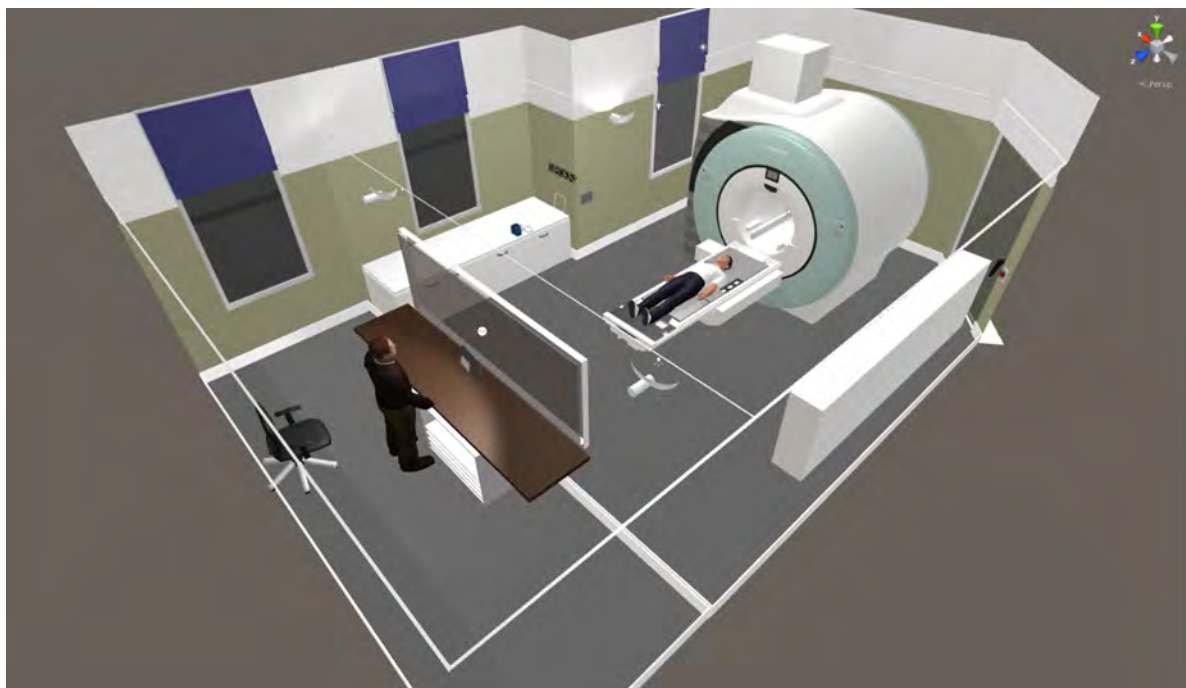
Prototype 3D model of MRI and control room
